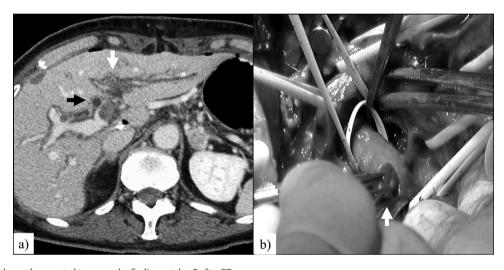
Postoperative enhanced computed tomography findings at day 5 after PD.
